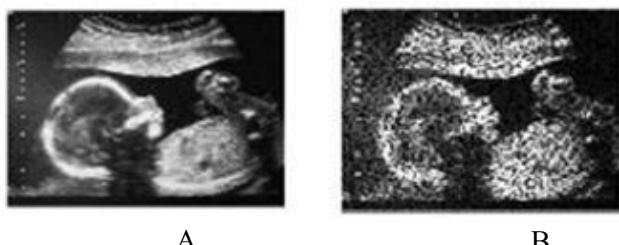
A – Original ultrasound image, B – Noisy ultrasound image distorted with speckle noise variance of 0.3.
